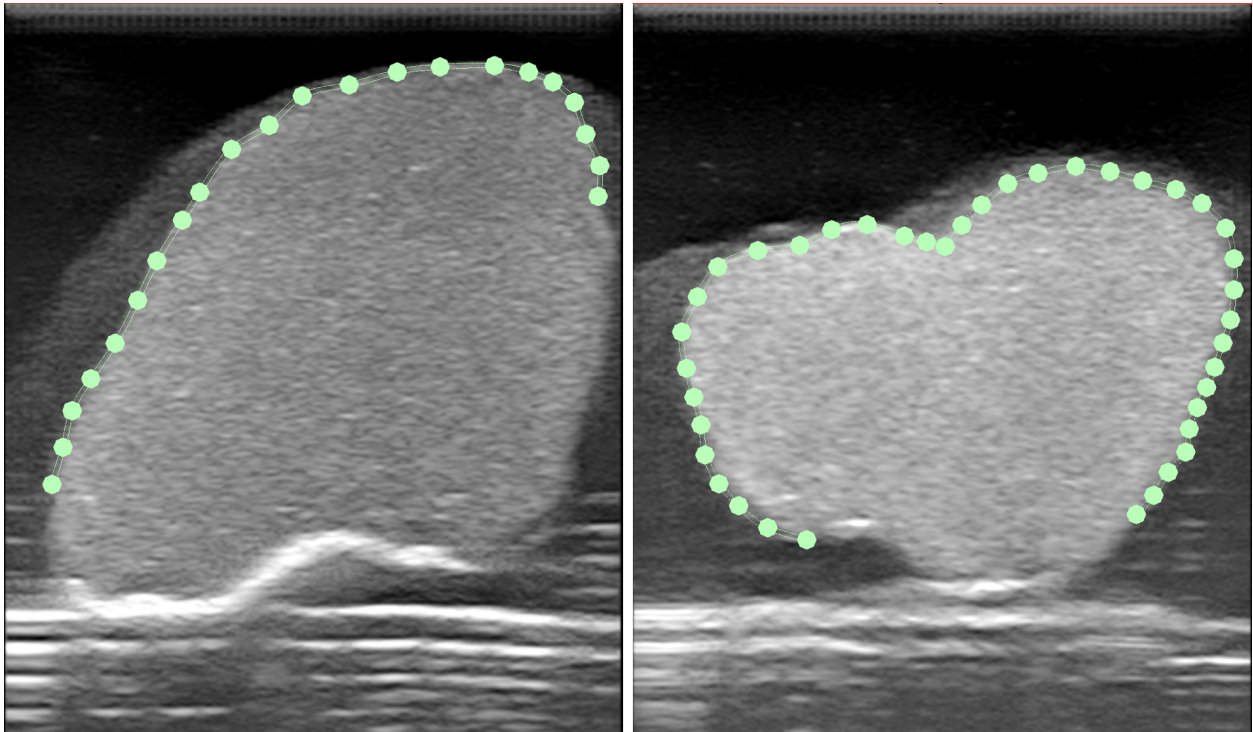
Examples of segmented ultrasound images used to acquire kidney surface data for image registration. In each image, several surface points were manually identified, then additional surface information was approximated by interpolating a spline between the anchor points.
